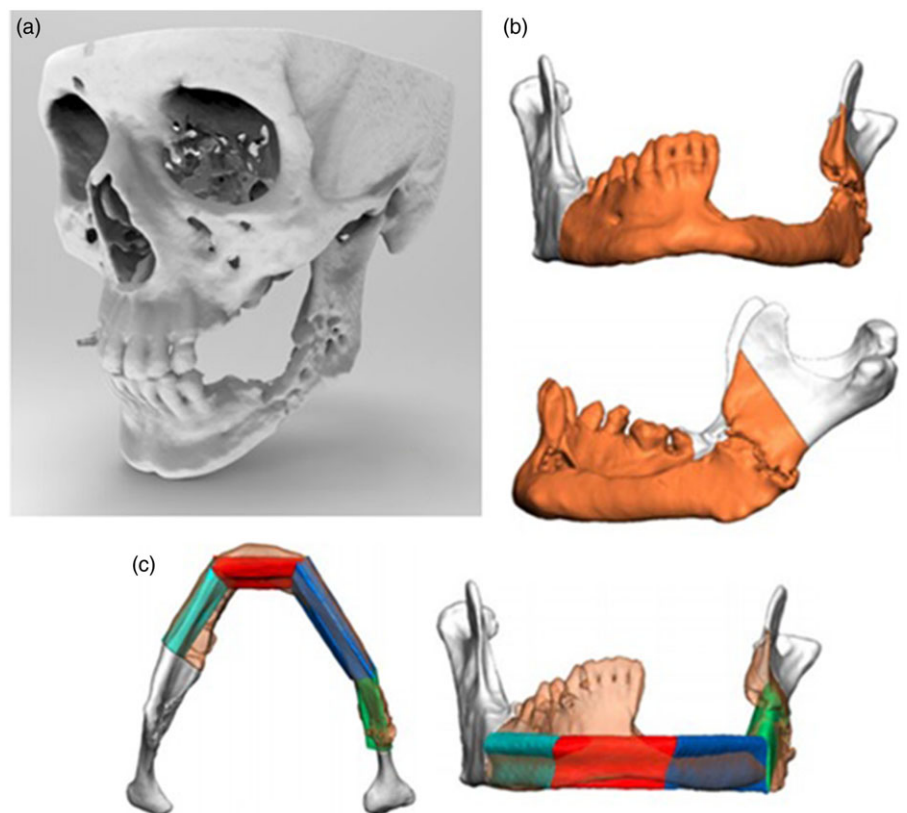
Virtual surgical planning for resection of the mandible. (a) High definition CT is used to create a rendered image of the maxillofacial skeleton. (b) Radiological and clinical assessments guide the surgical planning. (c) Bone sections (in teal, red blue and green) taken from the patient's fibula, guided by 3D-printed cutting guides form the reconstructed section replacing the resected mandible.
